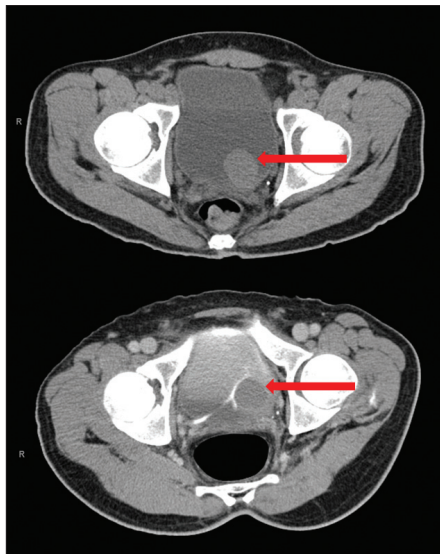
CT urogram shows a urinary bladder mass having higher attenuation density with the pre-contrast images. The lesion does not demonstrate any significant enhancement
